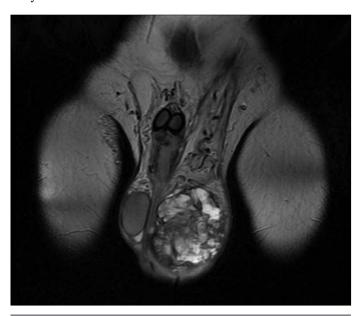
MR imaging showing left testicular solid mass on sagittal FSE T2 signal MR: magnetic resonance; FSE: fast-spin echo
